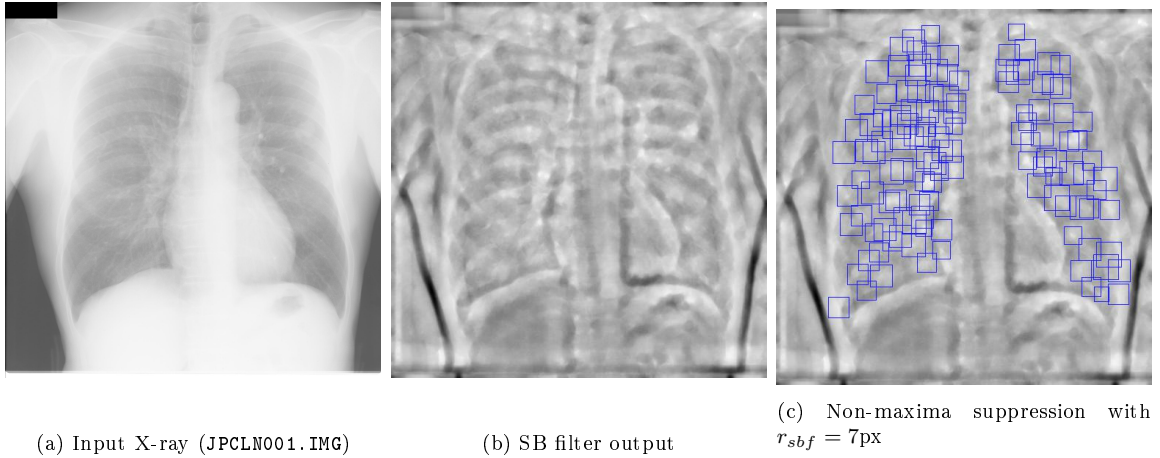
Visualization of the candidate detection stage. (a) Input x-ray (JPCLN001.IMG); (b) SB filter output; (c) candidates detected selecting the local maxima with $r_{sbf} = 7\text{px}$ on the neighborhood region.
